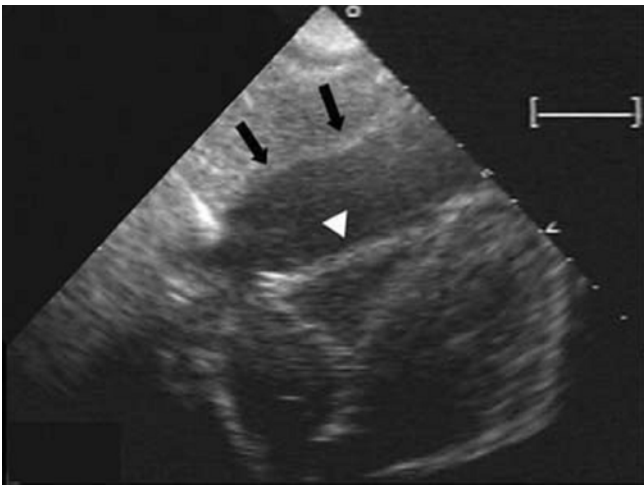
On the subcostal view, echocardiography showed diffuse pericardial effusion around the anterior and lateral wall (arrows) and with diastolic collapse of the right ventricular wall (white arrowhead).
